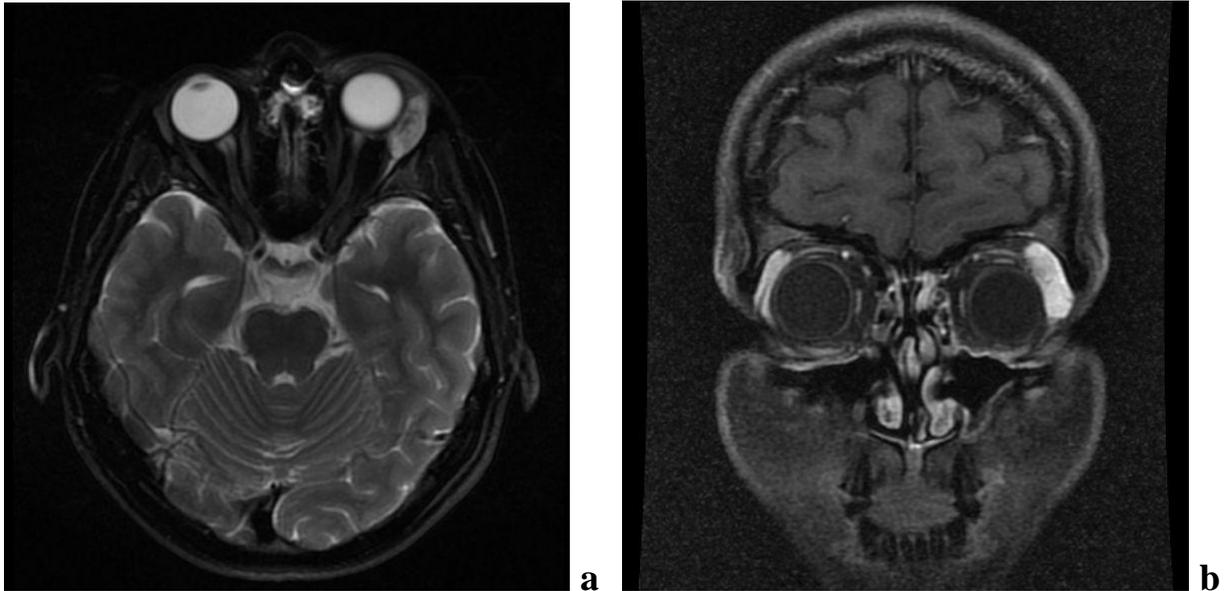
(a) Axial T2 weighted MR image with fat suppression and (b) coronal T1 weighted postcontrast MR image with fat suppression showing tumor mass in the left lacrimal gland area.
